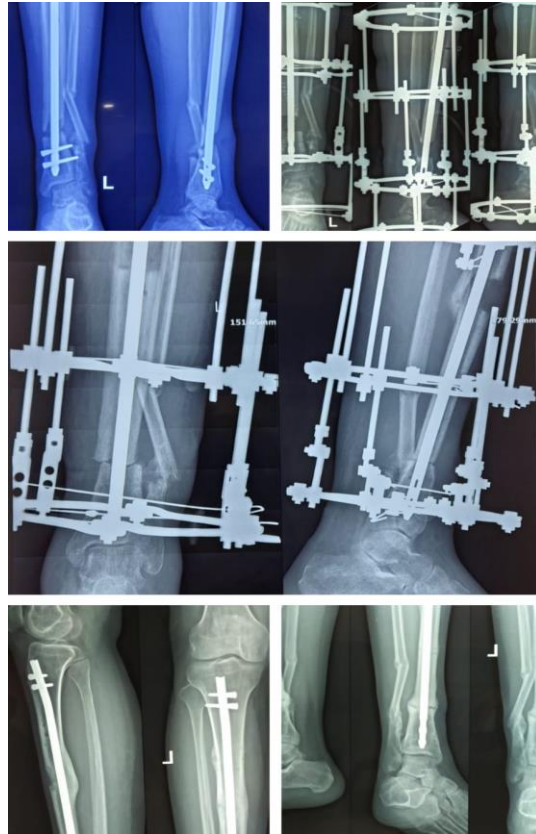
Radiographs of a 27 years old male patient with tibial fracture operated with SIGN Nail and application of Ilizarov frame
